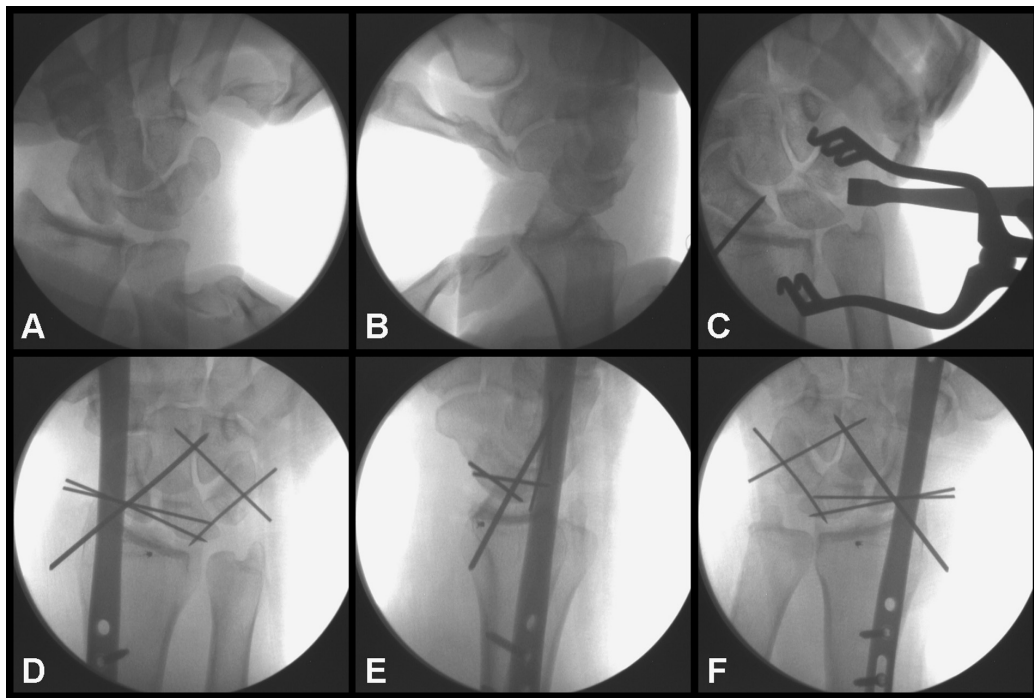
Selected intraoperative fluoroscopic images demonstrate: (A) significant ulnar carpal translocation, (B) bidirectional radiocarpal instability with stressing, (C) perilunate injury as evidenced by disruption of Gilula's arcs at both the SL and LT joints (appreciated on fluoroscopy and confirmed with arthrotomy) with associated widening of the midcarpal joint, (D, E) final radiographs (pronated PA and lateral views) following repairs showing subtle widening of the DRUJ, dorsal distal ulna subluxation, and (F) reduction of the DRUJ with supination (supinated AP view). AP, anteroposterior; DRUJ, distal radioulnar joint; LT, lunotriquetral; PA, posteroanterior; SL, scapholunate.
